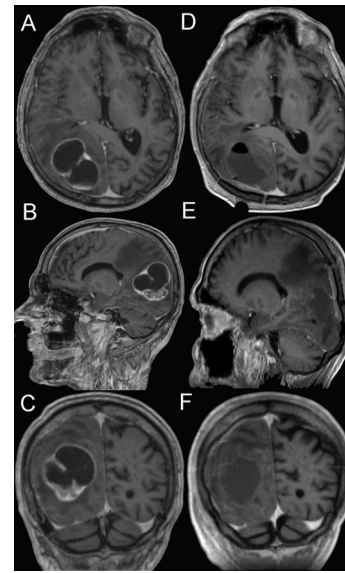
Case #5 (Table 1); MR images: axial T1 (A, D), sagittal T1 (B, E) and coronal T1 (C, F). All images are contrast-enhanced T1-weighted. Before surgery: fig. A, B, C images showing a right parieto-occipital tumor with a fleshy portion located at the level of the lower part. Postoperative images 2 days after surgery: fig. D, E, F images showing a good resection of the tumor.
